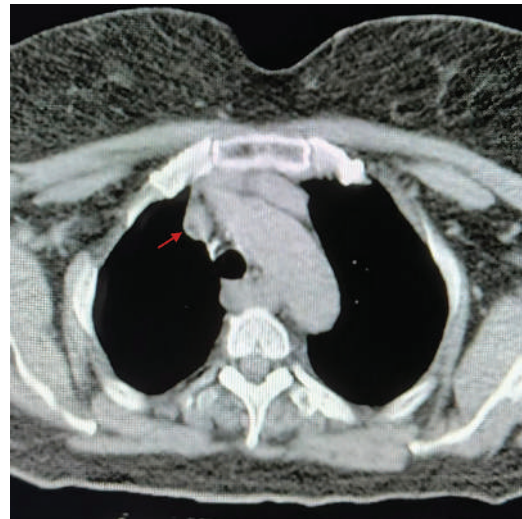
Aberrant right subclavian artery. Appearance of the aberrant right subclavian artery (red arrow) on preoperative CT scan.
